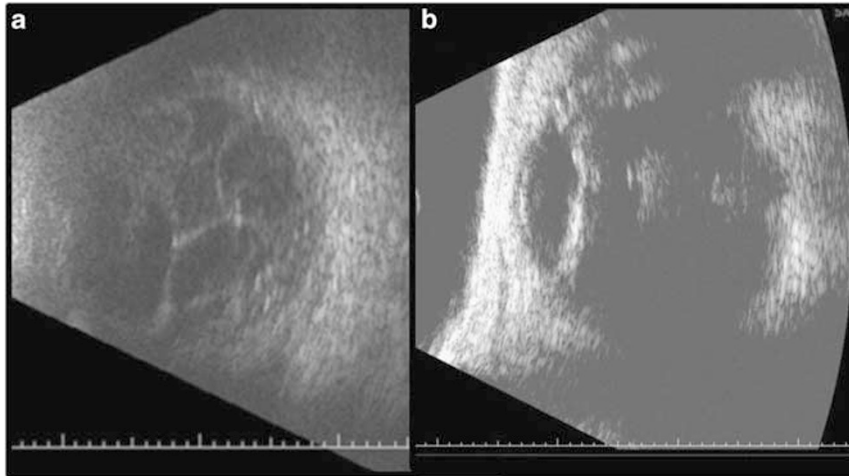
Ultrasonography in the diagnosis of postoperative endophthalmitis. (a) Classic appearance of vitreous stands and membranes on B-scan ultrasound. Variations in gain can alter the appearance of the vitreous opacities. (b) Capsular hyperreflectivity in a case of delayed onset endophthalmitis with dense intracapsular deposits. The vitreous contains some dense deposits but is not diffusely infiltrated. Absence of vitreous inflammation or opacities is suggestive that endophthalmitis is not present, except for limited anterior forms.
